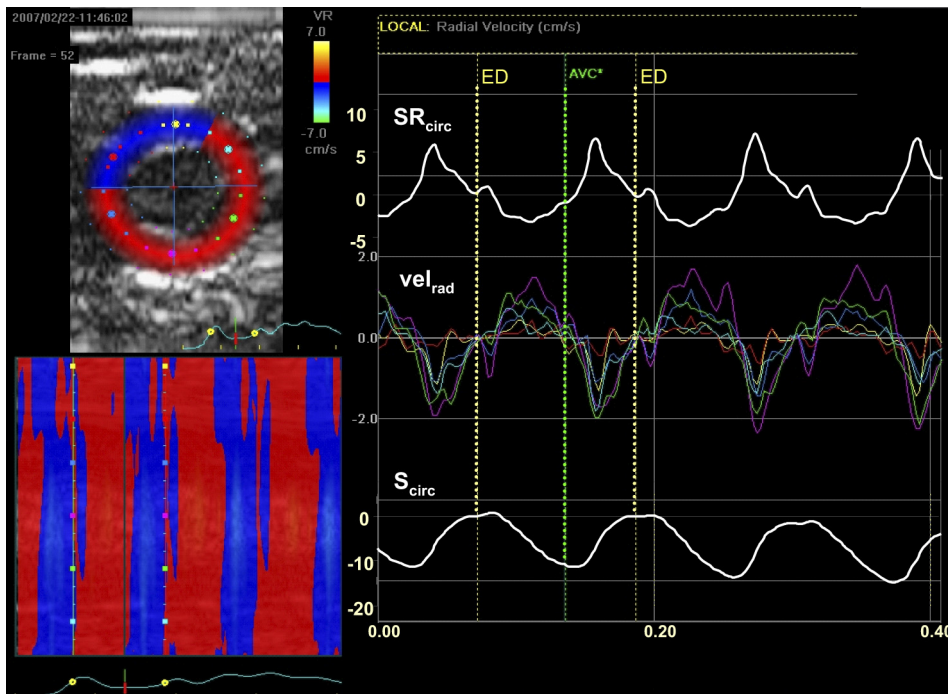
Selection of end diastole (ED) and end systole (ES) to determine left ventricular (LV) circumferential strain (S_{circ}) and radial strain (S_{rad}) by two-dimensional speckle tracking echocardiography. ED was defined as a crossover point from blue to red in a radial velocity (vel_{rad}) color M-mode map and usually coincided with the crossover points of the global S_{circ} rate (SR_{circ}) curve (top trace) and of the segmental vel_{rad} curves (middle traces). Please note that in some regions of the color M-mode map, the red color during systole was briefly interrupted by a narrow strip of blue corresponding to the end of isovolumic contraction, which was, in turn, followed by a constant red color, indicating ejection. ES was defined as the minimal LV cross-sectional area and usually coincided with the end of the systolic wave of the global SR_{circ} curve and of the segmental vel_{rad} curves. The yellow and green vertical lines represent ED and ES, respectively. AVC, aortic valve closure. S_{circ} curve shown on the bottom trace.
